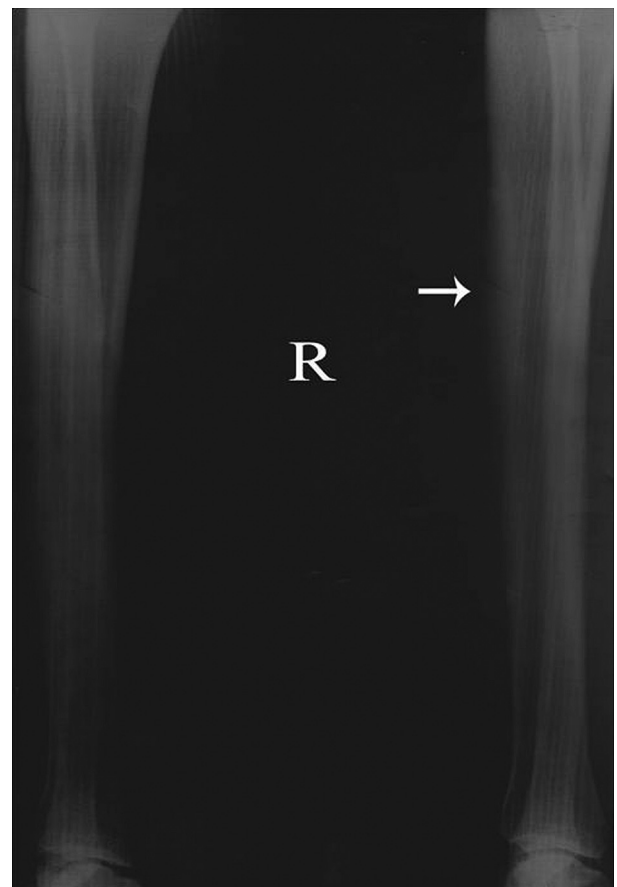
Radiograph of the right-leg shin showing incomplete fracture (white arrow) of the anterior cortex of the tibial middiaphysis.
